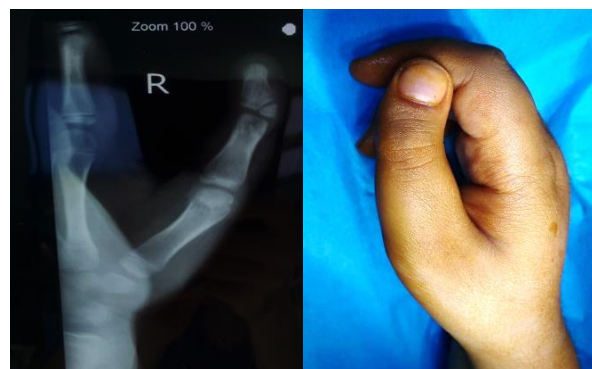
A. Preoperative image of triphalangeal thumb (TPT) with a small delta phalanx; B. Preoperative radiographic image of deviation in the right hand thumb
